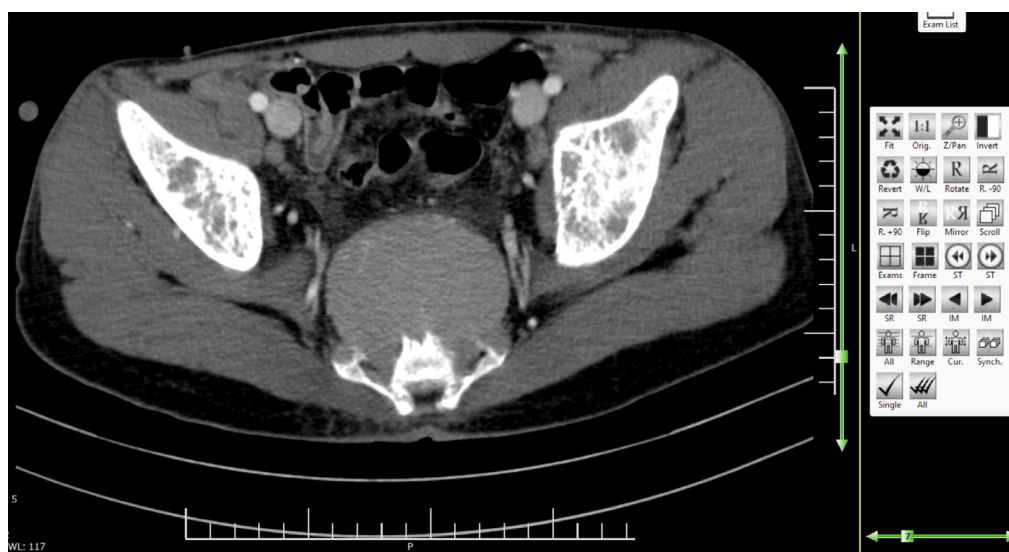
Contrast-enhanced abdominopelvic Computed Tomography (CT) scan
